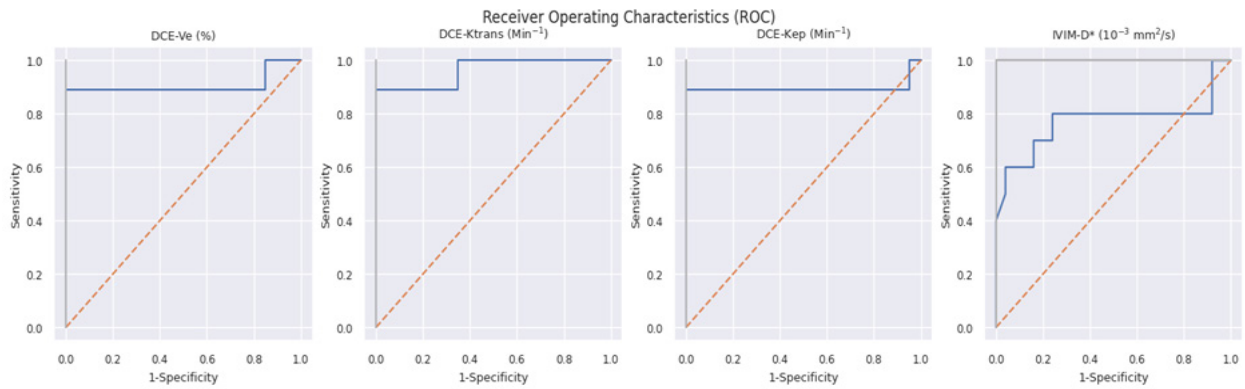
Receiver Operating Characteristics (ROC) of Predictive MRI Parameters.
